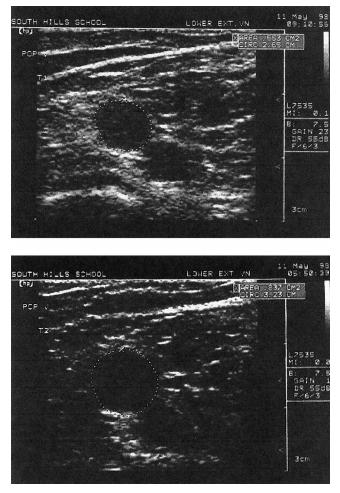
Upper panel, example sonographic exploratory cross-sectional view of the posterolateral ankle, locating the bifid (split) posterior tibial vein (PTV). The left bifurcation was selected for this subject and traced, producing an area calculation for trial 1 pre-8 h of standing. Lower panel, the identical view of the left bifurcation of the PTV was traced for trial 2 at the end of the day after standing for 8 h with the area calculation produced.
